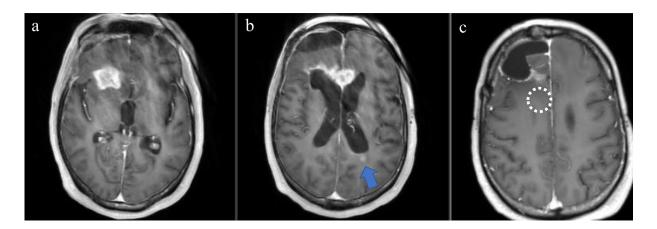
Recurrence of the tumor. (A, B) The follow-up MRI, showing the recurrence of GBM at the right frontal lobe extending to the corpus callosum. Dissemination is visible next to the left lateral ventricle (arrow). (C) Preoperative MRI just before the second surgery, showing no enhancement in the area enclosed by dotted circle, where a newly enhanced lesion would appear.
